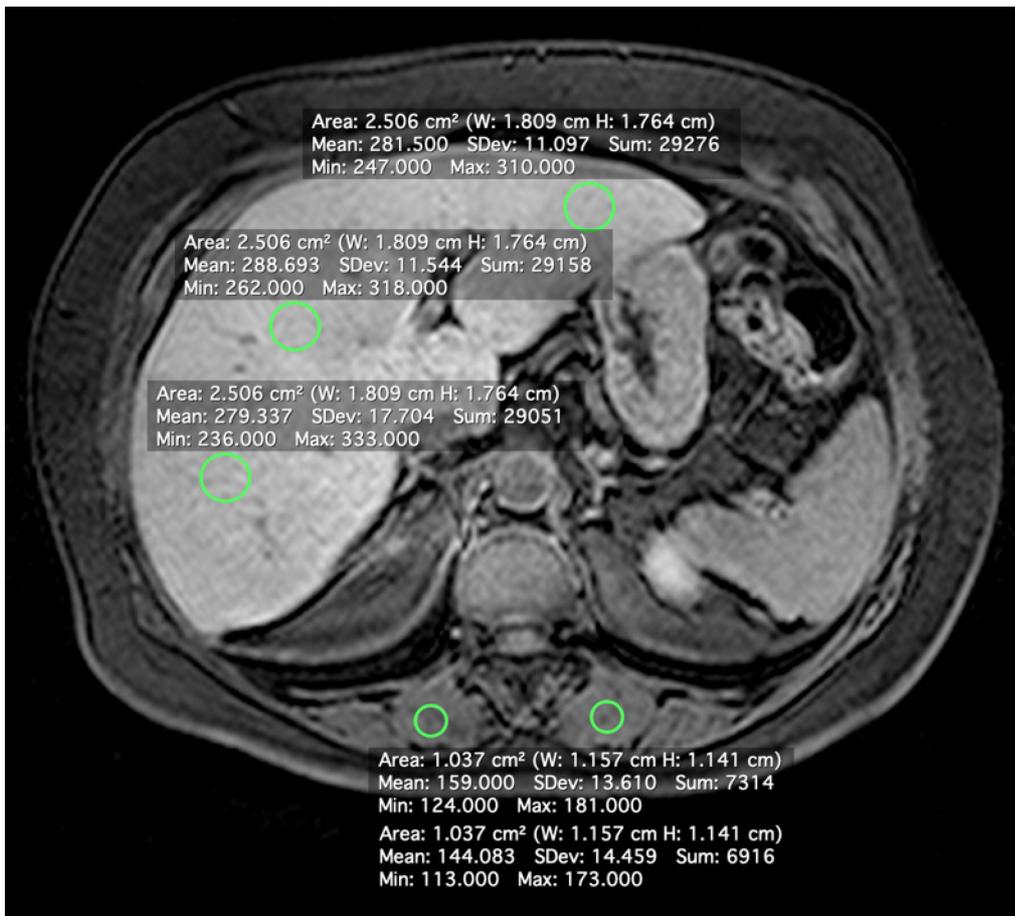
Axial magnetic resonance image showing the positions of regions of interest for the measurement of signal intensity of the liver parenchyma and paravertebral muscles.
